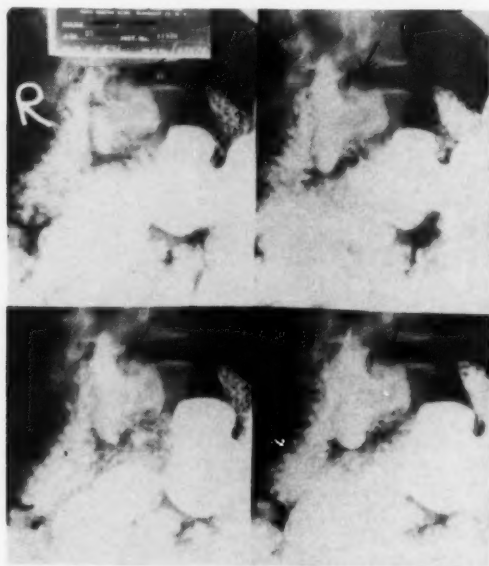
Spot roentgenograms of duodenal bulb of the patient in Case 2, showing an indentation of the lesser curvature. Exploration revealed a pedunculated leiomyoma.
